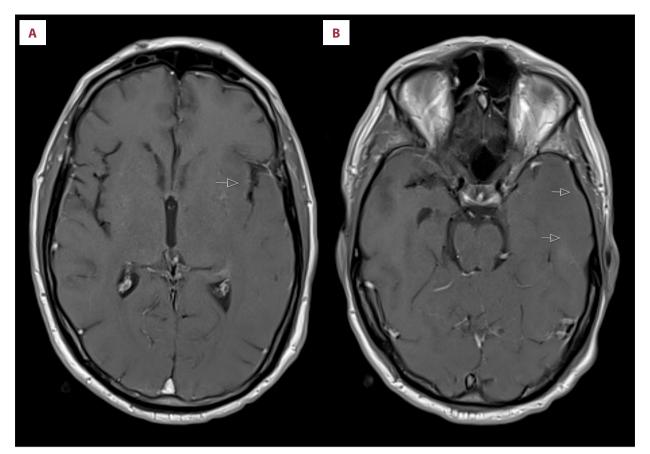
(A, B) Second axial contrast-enhanced T1-weighted MRI showing a marked decrease in the previously observed changes (arrows). In addition, a hypointense signal is observed in the medial surface of the frontal cortex, bilaterally (A).
